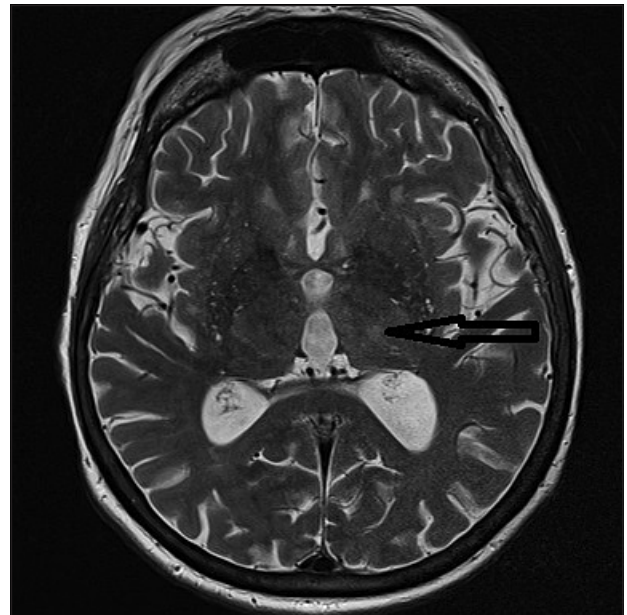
Brain MRI image which shows hyperintense lesion in VIM zone due to insufficient response to 130 Gy dose
